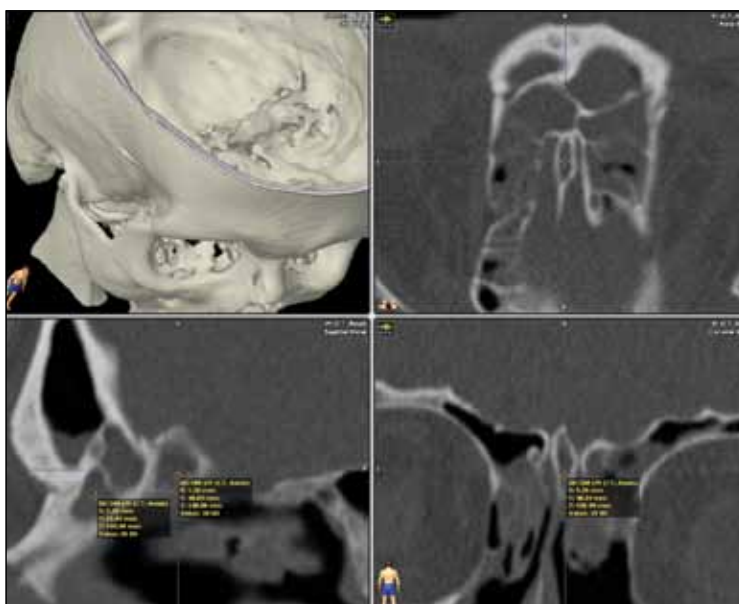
Measurement of tissue density using Hounsfield unit scale in a patient with an opacified pneumatized crista galli on sagittal and coronal planes CT scan
